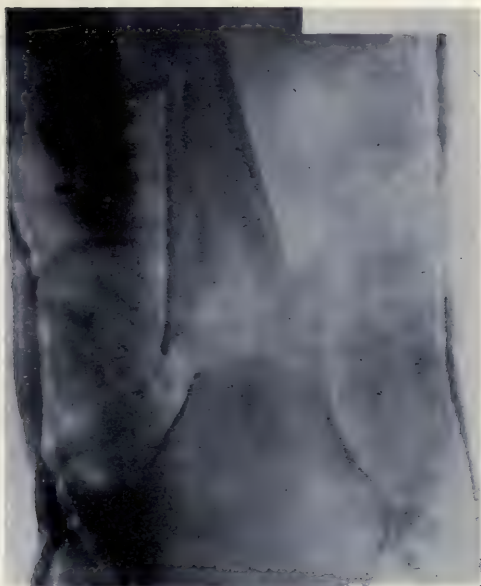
Anteroposterior x-ray of right femur before correction (Case II).
